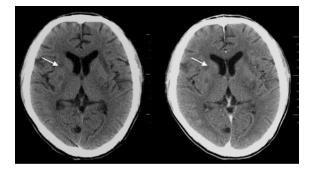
First cases of uncorrected diagnose cryptococcoma by CT; few small non-enhancing hypodense lesions at the right basal ganglion (arrow), likely to be cryptococcoma by CT. Final diagnosis was diagnosed to be lacunar infarction by therapeutic treatment. Other hypodense lesions at left basal ganglion and right occipital lobe were subacute and old infarction, respectively
